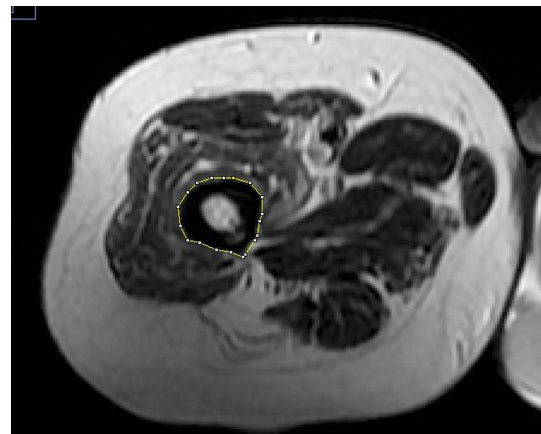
Calculation of right femoral bone and muscle tissue volumes on single axial T2-weighted MRI
